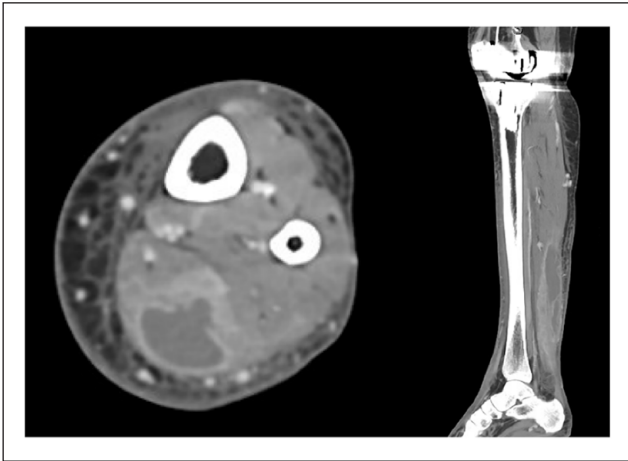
CT images showing left calf abscess.
